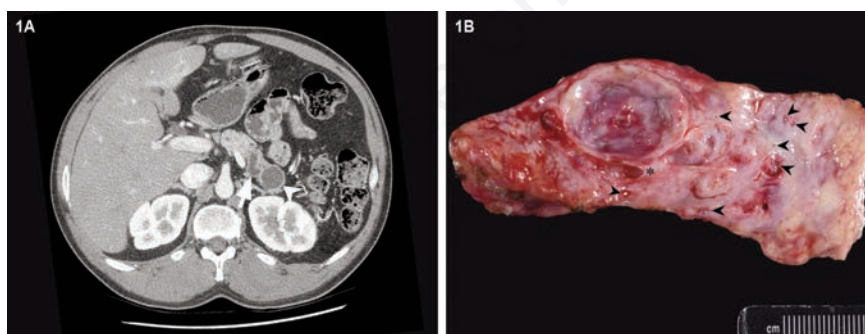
A) Computed tomography scan of the abdomen shows a cyst in the tail of the pancreas (arrowhead), which appears connected to the dilated main pancreatic duct (arrow). B) Gross photograph of the pancreatic tail reveals a 2.5 cm unilocular cyst adjacent to the dilated main pancreatic duct (asterisk). The surrounding parenchyma is fibrotic and contains multiple smaller cystic spaces (arrowheads); near the resection margin at right, the pancreatic parenchyma assumes a more normal gross appearance.
